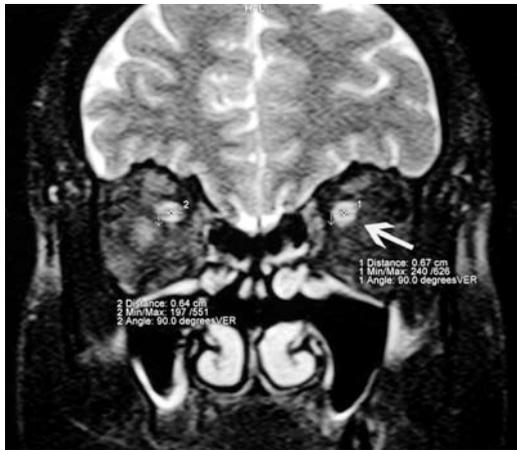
Coronal heavily T2-weighted MRI shows hyperintense fluid in the expanded subarachnoid space due to increase of total fluid. In the left eye, the white arrow shows that the optic nerve thickness was measured as 0.50 cm at the level of the trunk and 0.67 cm at the retrobulbar area. In the right eye, the optic nerve thickness was measured normally as 0.44 cm at the level of the trunk, and 0.64 cm at the retrobulbar area.
